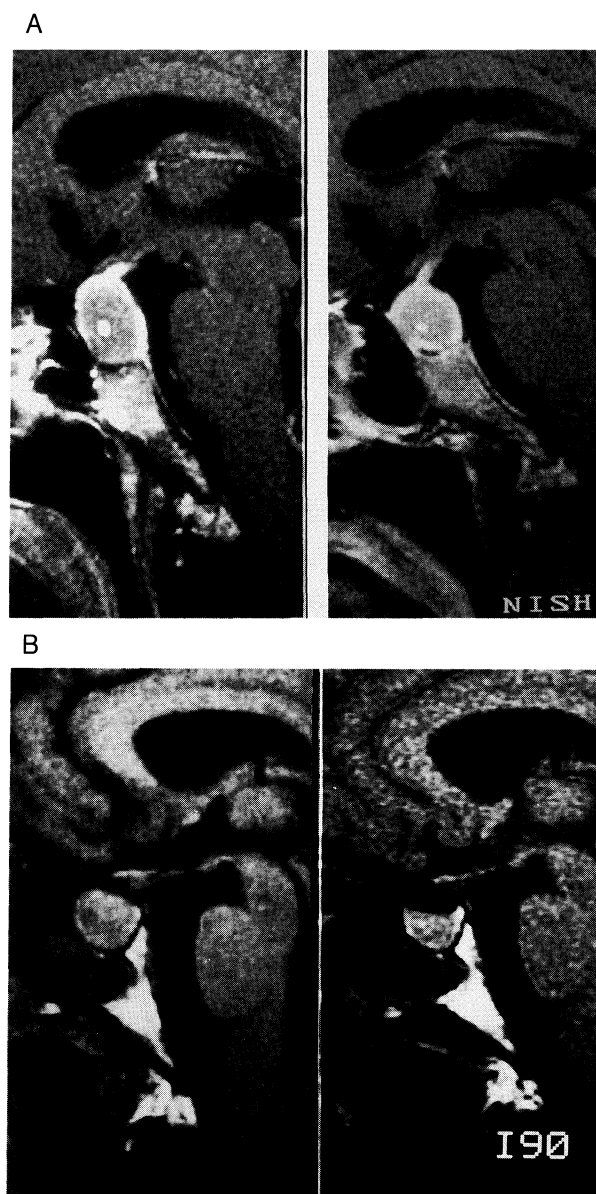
Sagittal sections of MRI before (left) and 4 weeks after (right) commencement of octreotide therapy (A, case 1; B, case 5).
